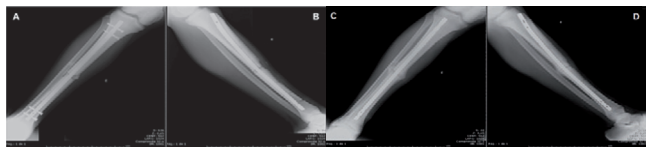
Radiographic images relating to patient number 32, who received a locked intramedullary nail with satisfactory treatment. A and B - Radiographic images on the first postoperative day with a locked intramedullary nail in the tibia for an exposed fracture of the tibial diaphysis that had initially been treated with an external fixator for five days. C and D - Radiographic images produced 18 weeks after the operation, with consolidated fracture of the tibial diaphysis.
